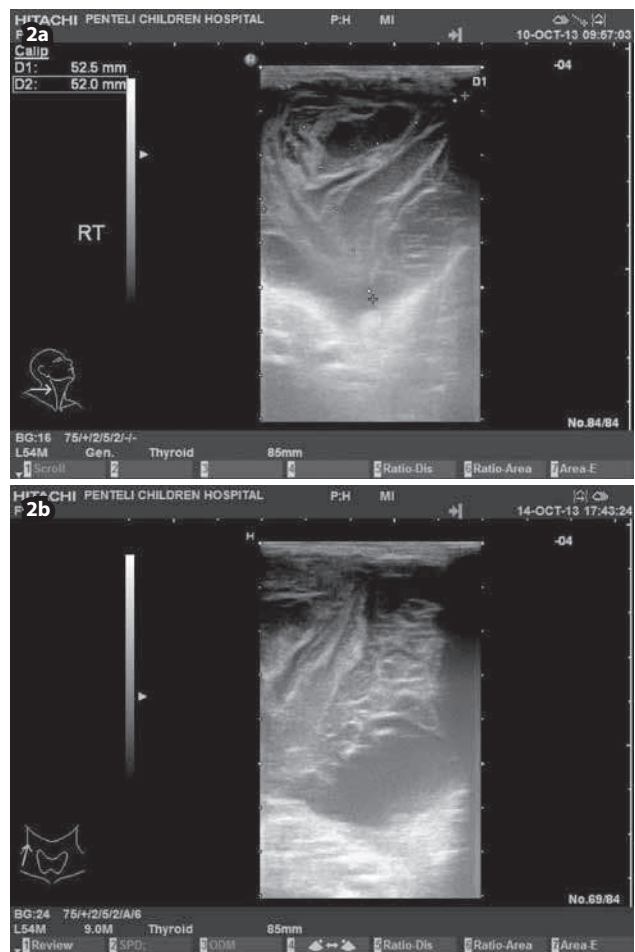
Ultrasonography (US) of right posterior neck, showing a lesion with internal septae, hyperechoic internal areas (hemorrhagic) and deep cystic component (a: axial view; b: sagittal view).
